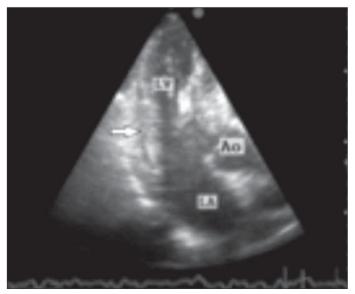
Video 1. Apical 5- chamber echocardiographic view of intramyocardial fissure (arrow)
